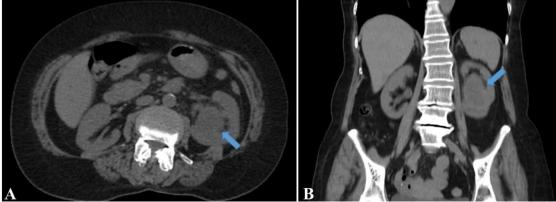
2.5 cm parapelvic nodular mass containing a cystic-solid lesion in the left kidney in CT imaging (A) Axial Plane (B) Coronal Plane
